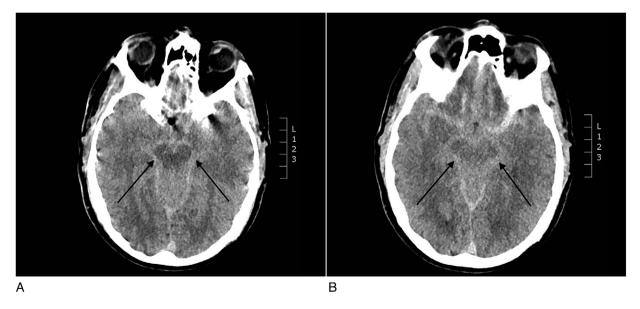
(A and B) CT brain with axial view demonstrating hyperdense gadolinium contrast in the basal cisterns extending into the Sylvian fissure
